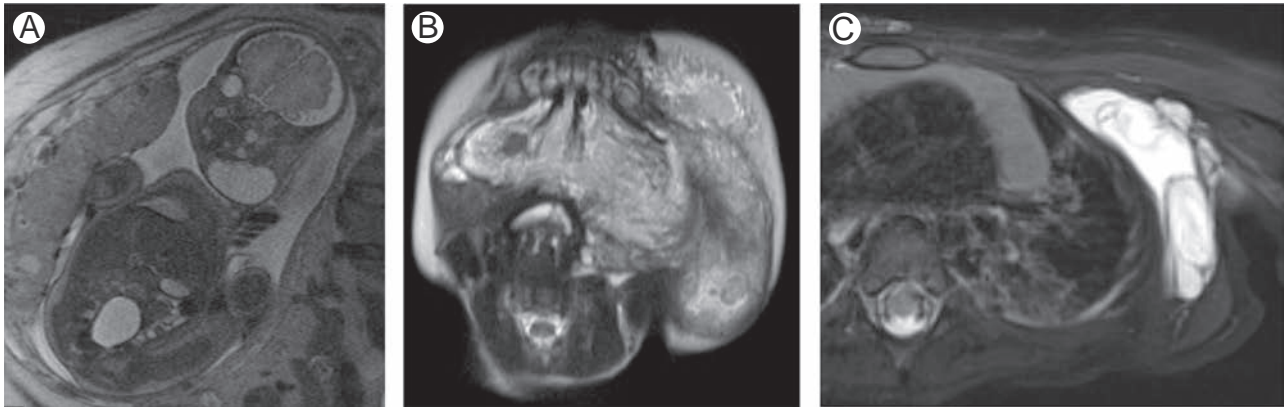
T2-weighted images showing different types of lymphatic malformations. (A) Prenatal MRI shows a macrocystic malformation involving neck. (B) A 3-month-old male with a cervical microcystic LM extending into the floor of the mouth. (C) A 10-month-old male with a left axillary mixed LM.
